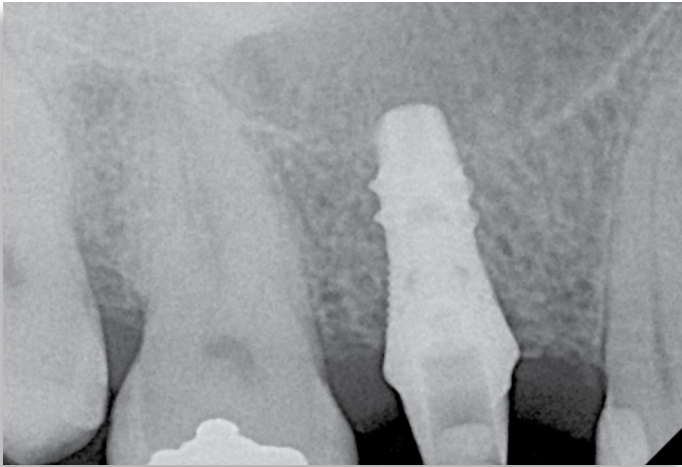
A radiograph is taken to ensure a complete seating of the abutment into the body of the implant.
